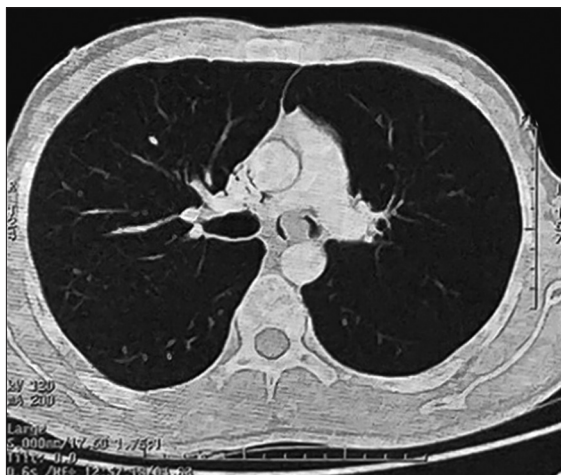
Computed tomography scan showing endobronchial mass in the left main bronchus
